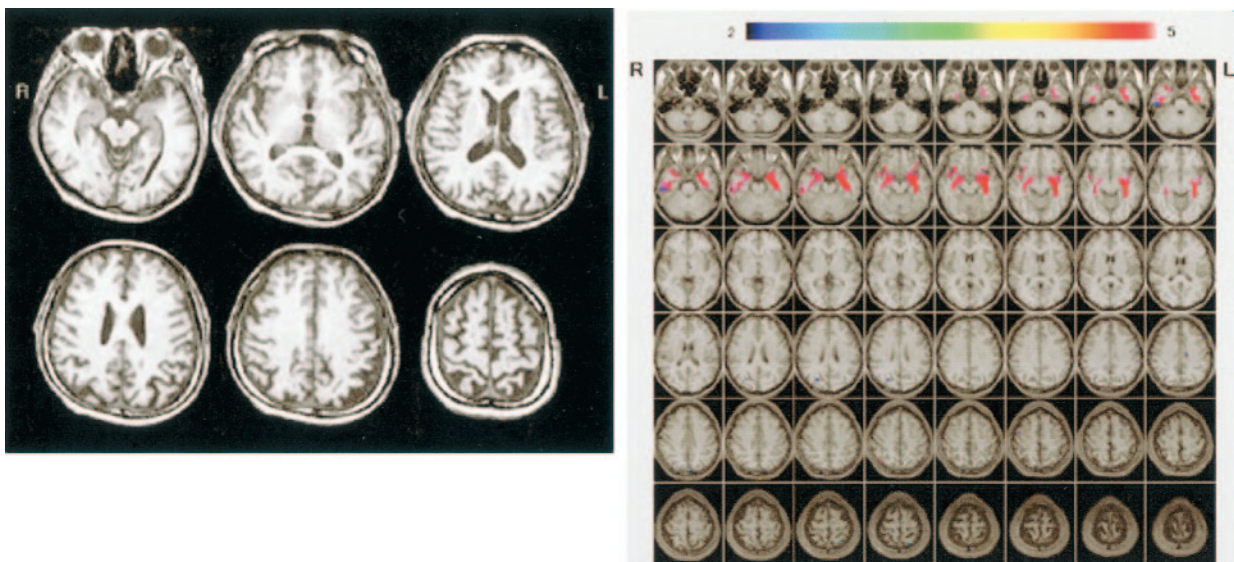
A and B, Conventional MR images (A) and Z score images (B) in a 73-year-old healthy control subject (MMSE score = 30). The left parietal lobe seems to be atrophied on the conventional T1-weighted images, although the Z score map demonstrates that there is no significantly atrophied area.
